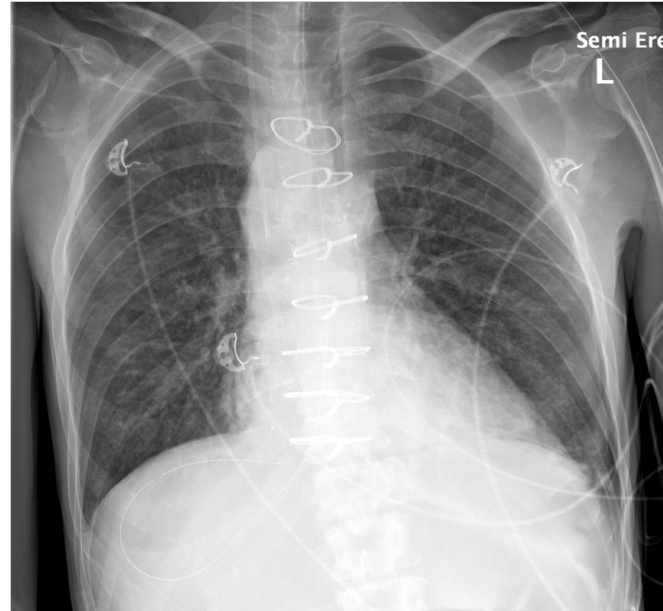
Chest radiograph 11 days after surgery reported by radiology as minor bilateral lower lobe atelectasis
